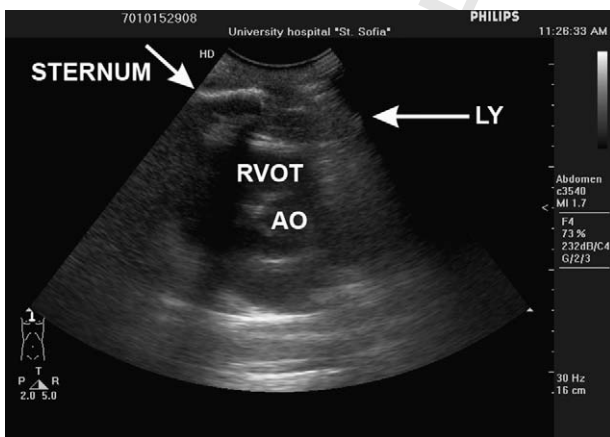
Sonography of the sternum, the tumor mass (LY) and the heart with 5 MHz sector transducer using abdominal preset revealing the close proximity of the right ventricular outflow tract (RVOT) to the punctured area.
